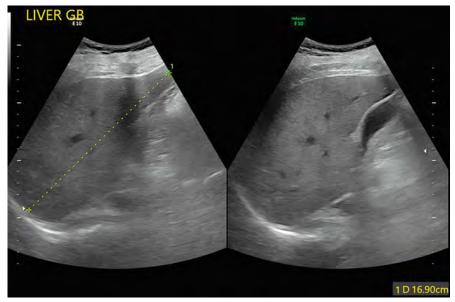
Ultrasonography of the abdomen reveals enlarged liver ~16.9 cm with normal echotexture suggestive of hepatomegaly
